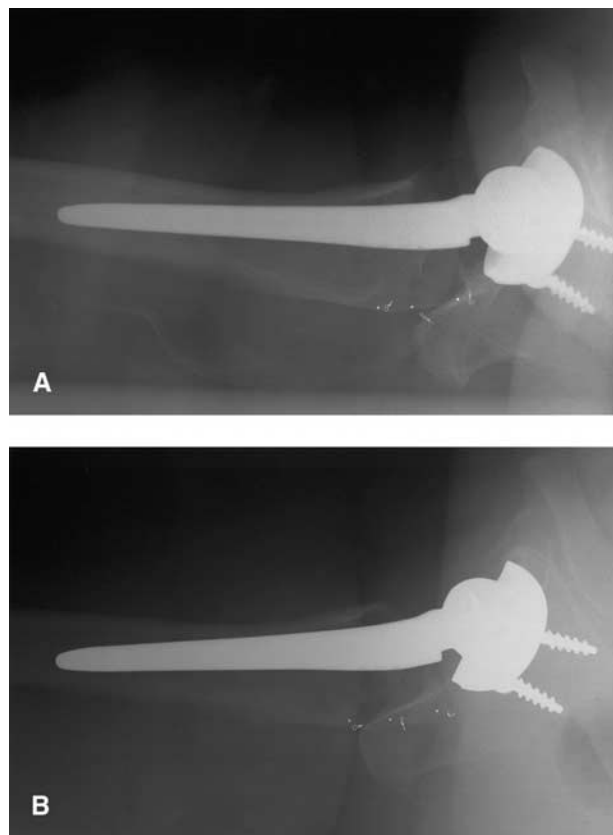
No failure of the repaired short external rotator muscles. Reference points are $< 2.5\text{ cm}$ to each other in the radiographs obtained on the first postoperative day (A) and 3 months postoperatively (B).
